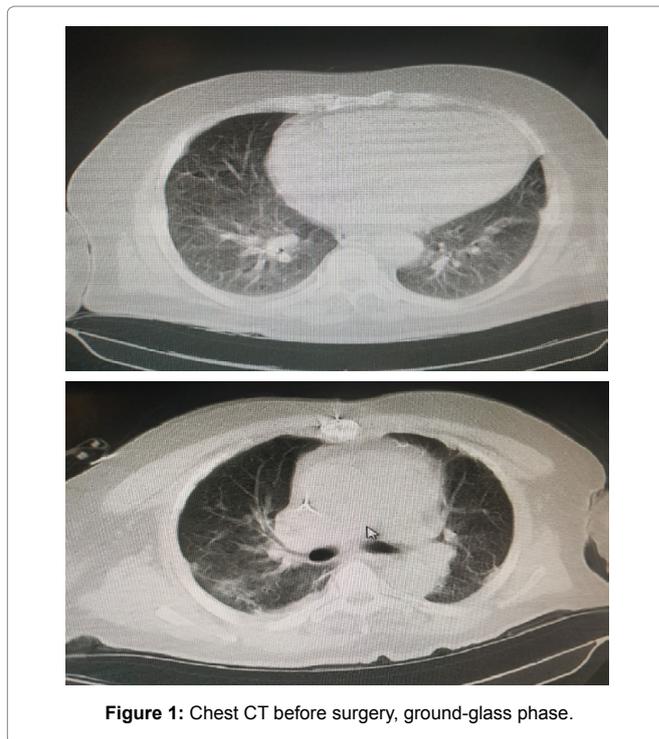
Chest CT before surgery, ground-glass phase.
